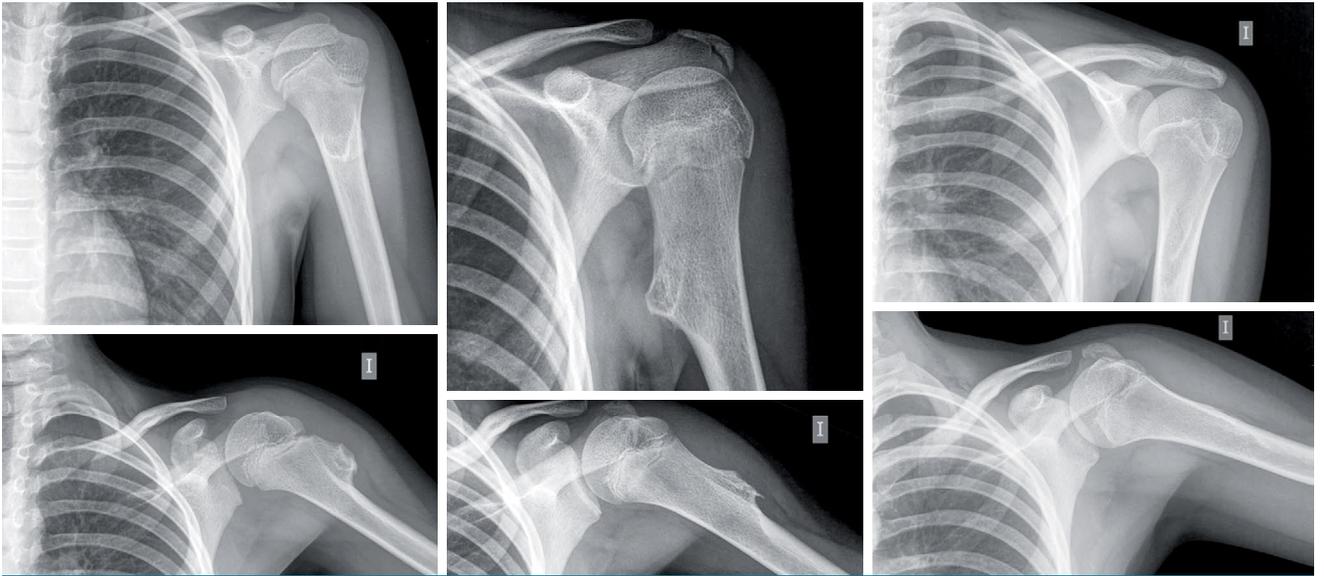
Anteroposterior radiographies of the left shoulder. A 10-year-old boy with an osteochondroma in proximal humerus followed by X-ray for three consecutive years.
